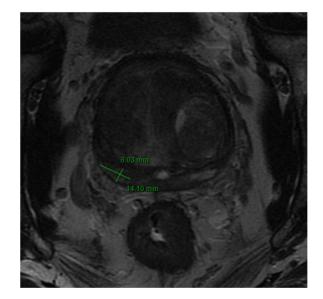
A 71-year-old man with history of favorable intermediate-risk prostate cancer (cT1c, GS 3+4, 5/18 positive cores, PSA 8) post definitive prostate SBRT ending in August 2019 and biopsy on that year confirming max GS 3+4, multifocal disease. Pretreatment multiparametric 3.0 Tesla imaging, including multiplanar T2weighted images, diffusion-weighted images (including ultra high b-1500 images and ADC map), and dynamic contrast-enhanced images of the prostate. Pre- and postcontrast T1-weighted images of the pelvis were also obtained. One lesion was revealed: 1 right postero-medial, midgland, peripheral zone PI-RADS 4 lesion with size of 14×6 mm as measured on ultra high b-1500 image. A 14 \times 6 mm lesion is present on the T2-weighted image. Abbreviations: ADC = androgen deprivation therapy; GS = Gleason score; PI-RADS = Prostate Imaging Reporting & Data System; PSA = Prostate Specific Antigen; SBRT = stereotactic body radiation therapy.
